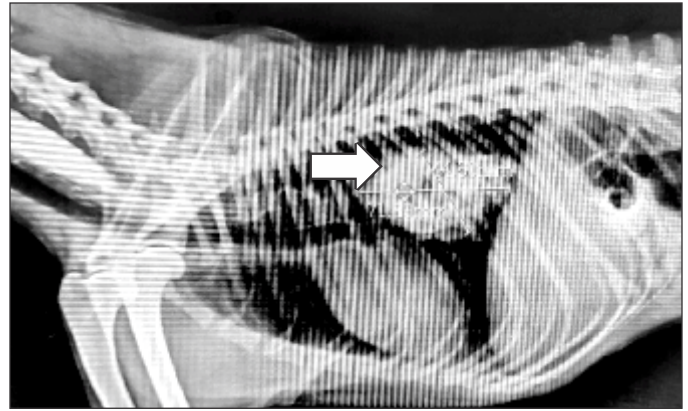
Contrast radiography revealed barium stasis in the cranial oesophagus (Arrow)
